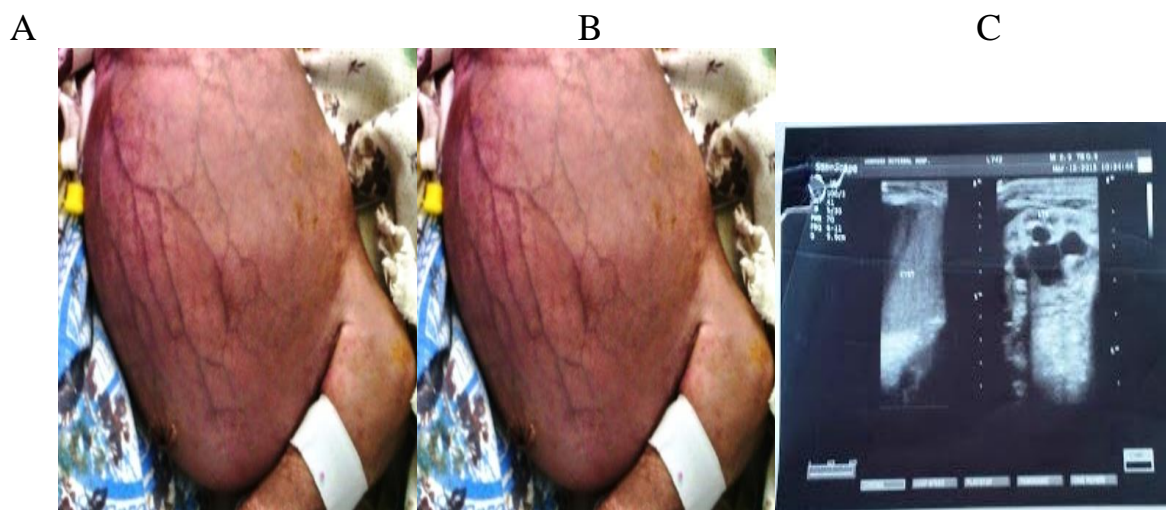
A: Photo of the abdominal swelling on Day, 21 B: Photo of abdominal swelling on Day 23, C: Ultrasound examination on Day 21.
